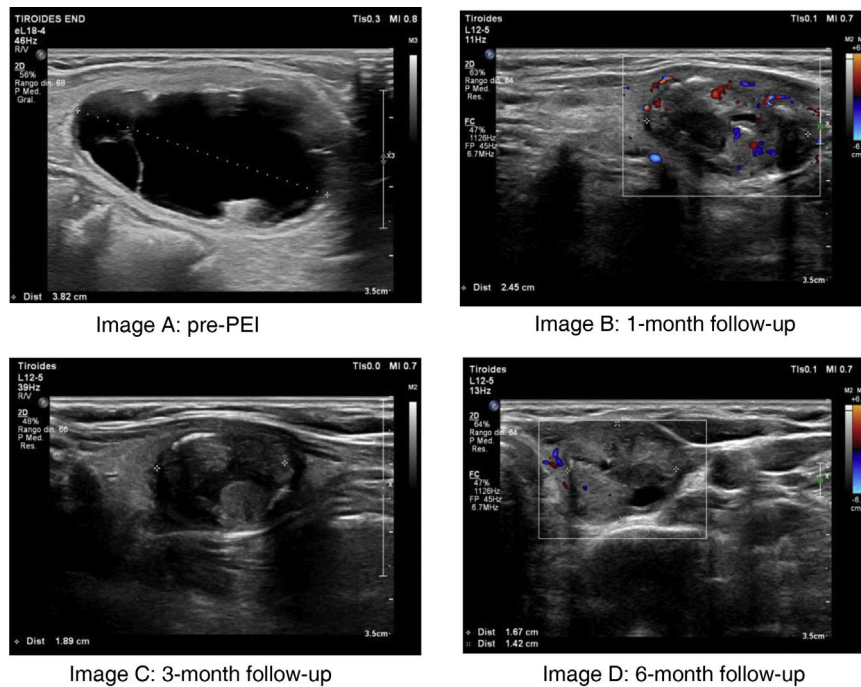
Initial and final ultrasound images of a thyroid nodule treated with percutaneous ethanol injection and ethanol aspiration. A) Pre-PEI cystic thyroid nodule with a maximum diameter of 3.8 cm (nodule volume, 17.10 mL). B) Color Doppler mode ultrasound image at the 1-month follow-up showing minimal peripheral Doppler uptake and a reduction in nodule size with a maximum diameter of 2.4 cm (nodule volume, 2.69 mL, VRR, 84.28%). C) Ultrasound image at the 3-month follow-up showing a reduction in nodule size with a maximum diameter of 1.89 cm (nodule volume, 1.72 mL, VRR, 89.94%). D) Color Doppler mode ultrasound image at the 6-month follow-up showing persistent minimal peripheral Doppler uptake and almost complete disappearance of the cystic component (final nodule volume, 1.64 mL, VRR, 90.42%).
